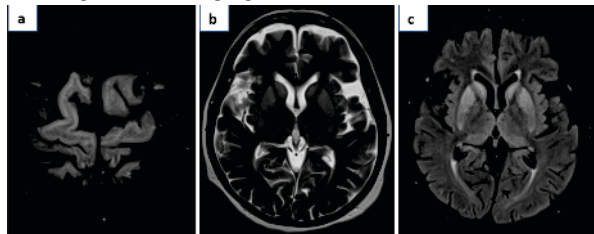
a) FLAIR axial section shows hyper intensities involving right superior frontal gyrus.
